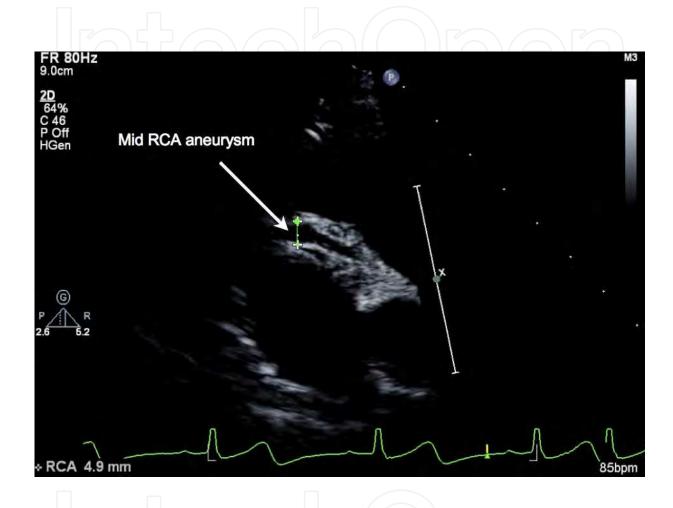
Off-axis parasternal short axis view demonstrating a fusiform aneurysm of the mid to distal right coronary artery (RCA) aneurysm
